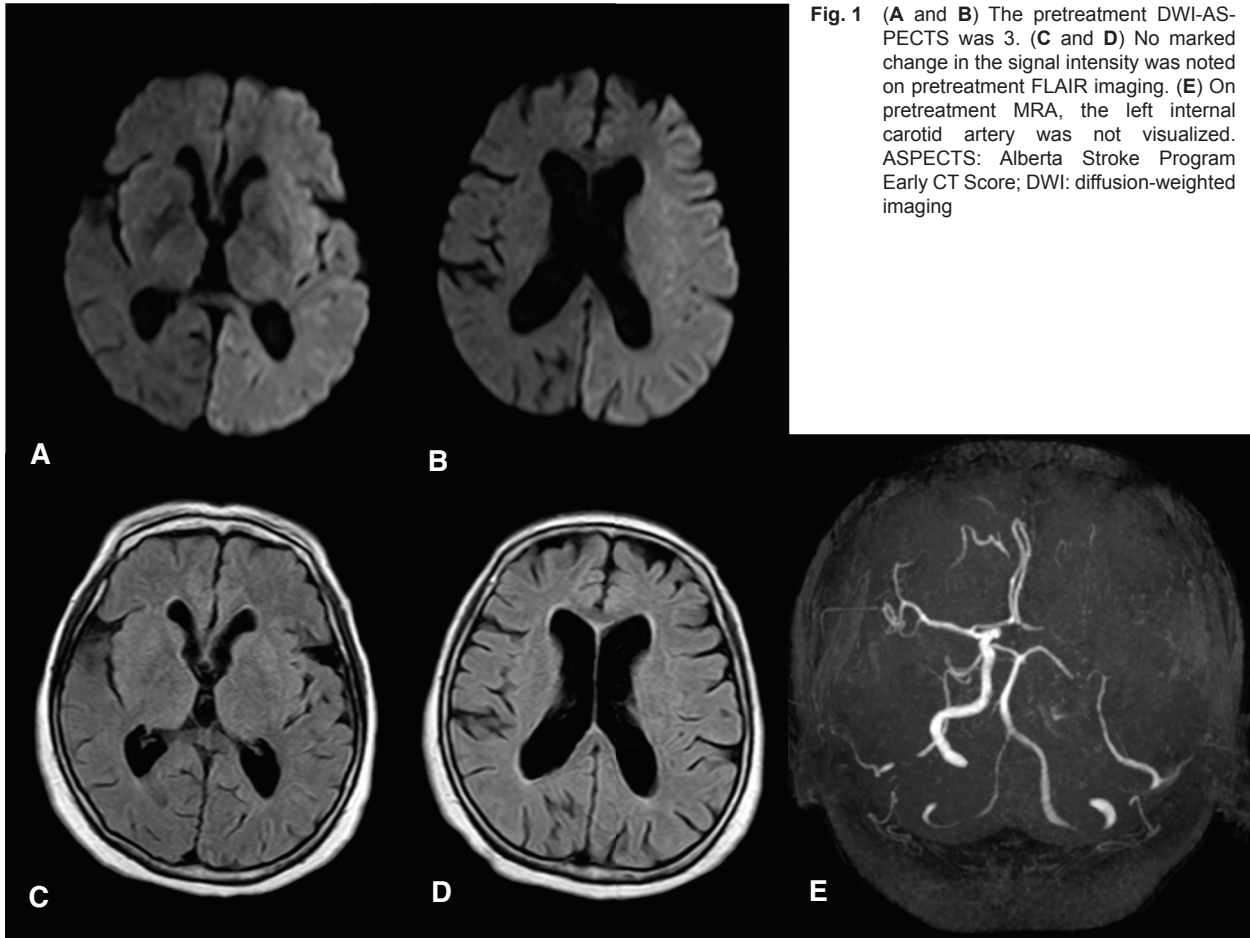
(A and B) The pretreatment DWI-ASPECTS was 3. (C and D) No marked change in the signal intensity was noted on pretreatment FLAIR imaging. (E) On pretreatment MRA, the left internal carotid artery was not visualized. ASPECTS: Alberta Stroke Program Early CT Score; DWI: diffusion-weighted imaging
